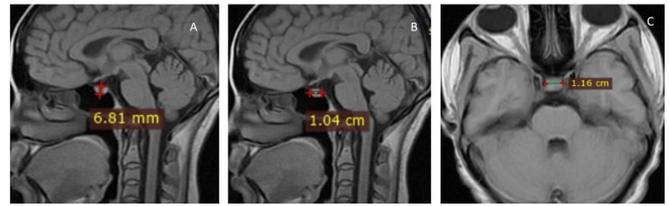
MRI images show pituitary measurements taken with spin echo sequence, TR 600, TE 14. A & B - T1-weighted sagittal images; C - T1-weighted axial image taken with TR 350 and TE 7.8.
